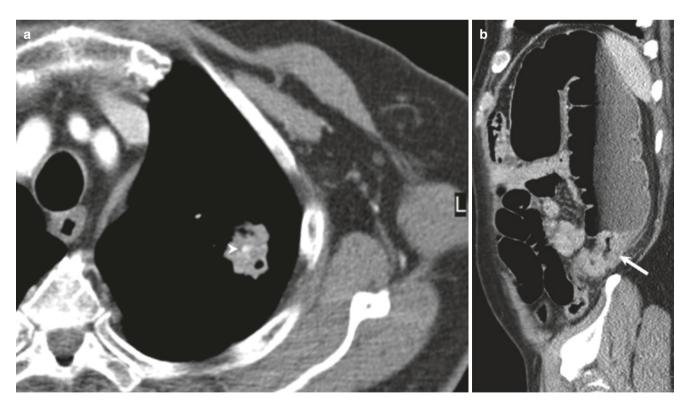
Calcified lung metastasis from mucinous adenocarcinoma of colon. (a) Contrast-enhanced axial CT image shows a soft tissue mass in left upper lobe with a small focus of calcification (arrowhead). (b)
